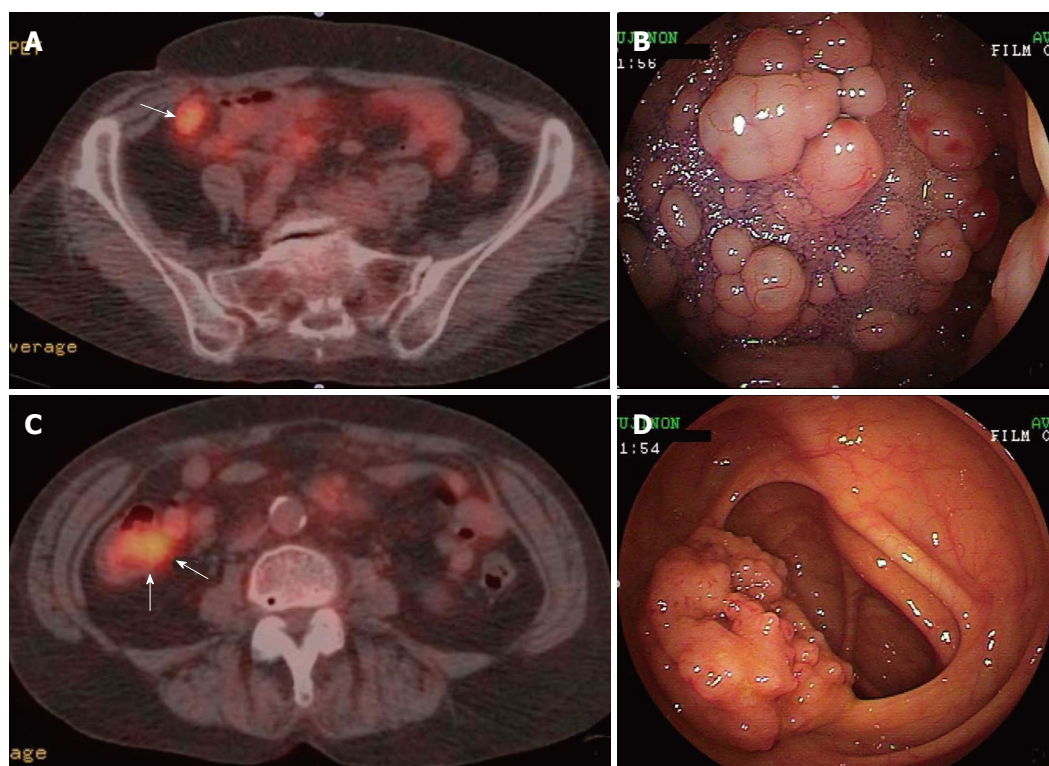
A 66-year-old woman with follicular lymphoma of the gastrointestinal tract. A, C: ^{18}F -fluorodeoxyglucose positron emission tomography combined with computed tomography in transaxial images showed focal hypermetabolic activities (maximum standardized uptake value, 6.73) in the lesion of the terminal ileum (A) (arrow) and the cecum (C) (arrows); B: The colonoscopic view with indigo carmine dye-spray of the terminal ileum. Numerous polypoid lesions of varying sizes (granules to small nodules) were densely clustered; D: The colonoscopic view of the ileocecal valve. Numerous polypoid lesions of varying sizes (granules to small nodules) were densely clustered.
